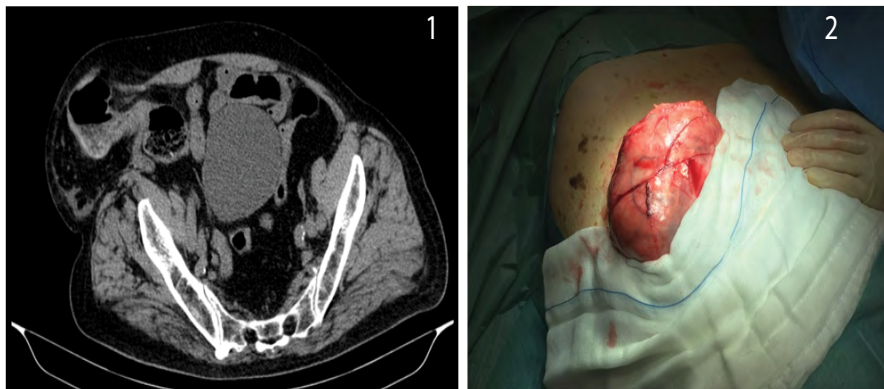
CT scan - Axial view of the large incarcerated Spiegel hernia on the right side.
